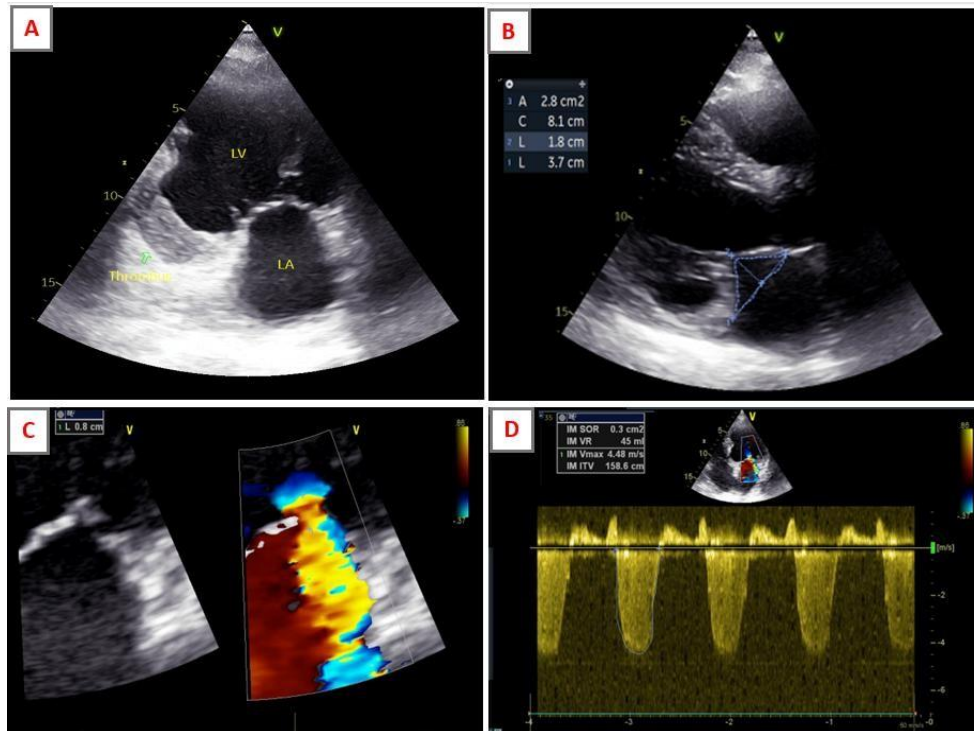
Transthoracic echocardiographic findings
